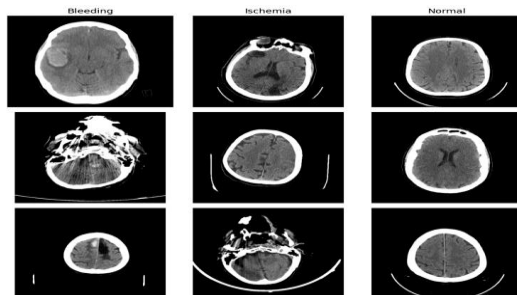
Sample image of stroke brain CT dataset
